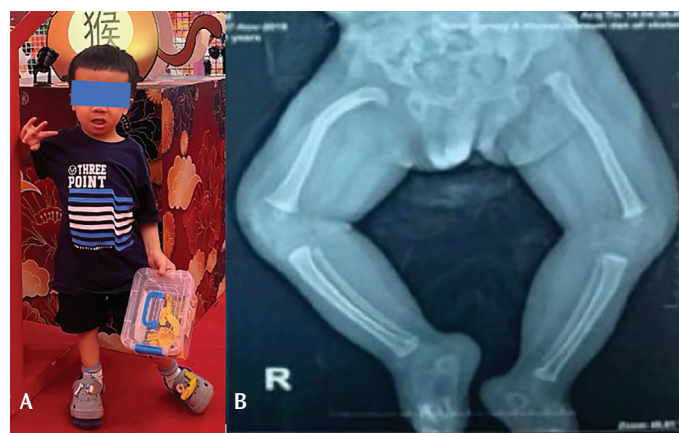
The second case, at 5.5 years old, his right foot was 3 cm shorter than the left one (A). The radiograph of the lower extremities in the second case shows bowing of the femurs, tibiae, and fibulae (B)
